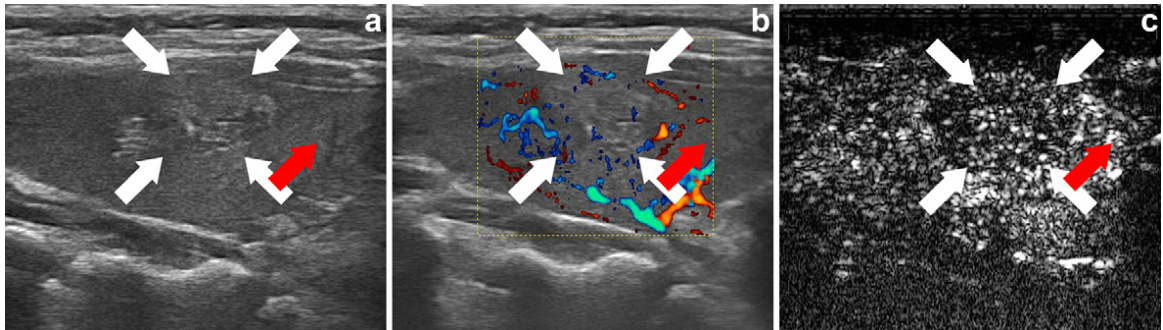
(a) High-resolution ultrasonography (HRUS) of a benign lesion (goiter nodule). The white arrows indicate the position of the lesion; the red arrow indicates healthy thyroid parenchyma. (b) Color Doppler image of the goiter nodule showing a weak vascularization (white arrows) compared with healthy tissue (red arrow). (c) Contrast-enhanced ultrasound imaging (CEUS) image of the goiter nodule. The lesion shows a low enhancement (white arrows) if compared with healthy parenchyma (red arrow).
